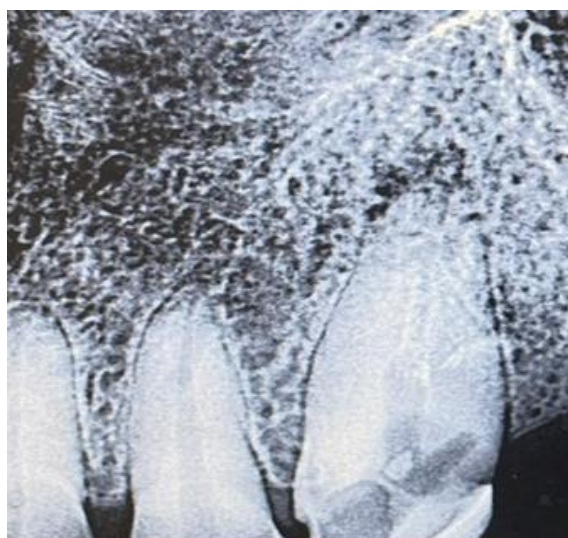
Pre-treatment showing a linear radiolucency suggestive of access opening. There is a mild periapical pathology present along with widening of the PDL spaces in relation to 23.
